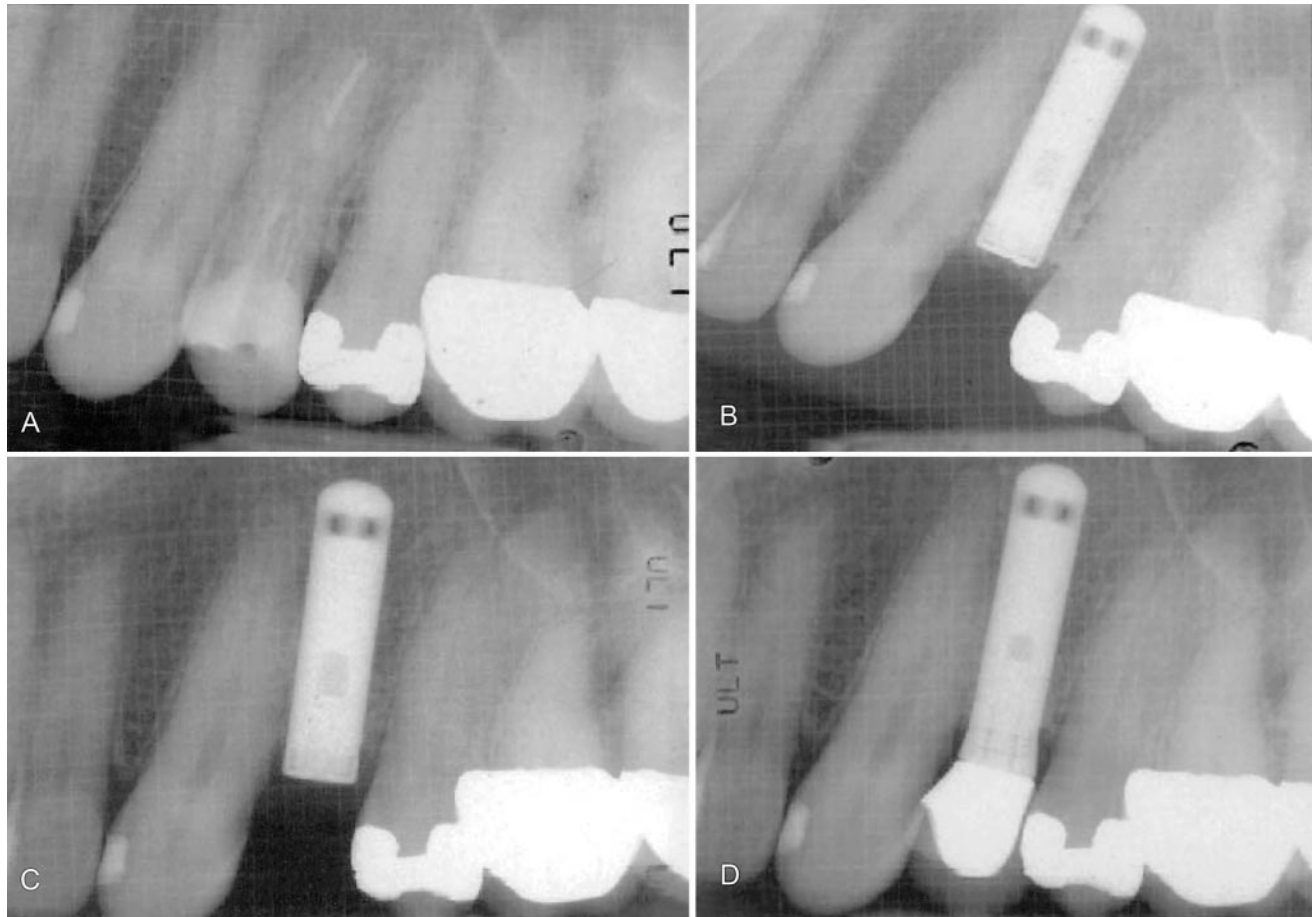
(A–D) Radiographic series showing initial condition of tooth 12, placement of implant and HTR graft, 6-month postoperative appearance, and crown in place after 6 months of loading. Slight gap apparent between crown and abutment, which was considered satisfactory by prosthodontist.
